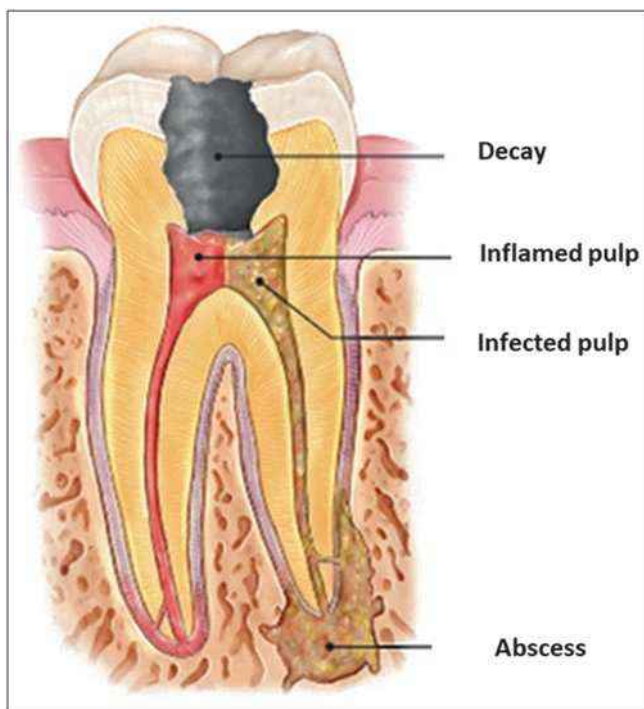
Dental caries progression to pulp and periapical tissues
